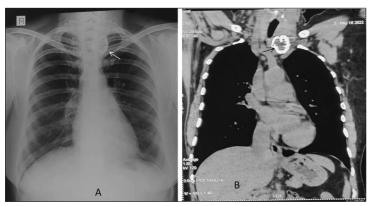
(A): X-Ray Chest PA view showing a round lesion with calcification in the root of neck (White arrow). Figure 1(B): CT Thorax coronal view showing the ring calcification in the superior mediastinum (Black arrow)
